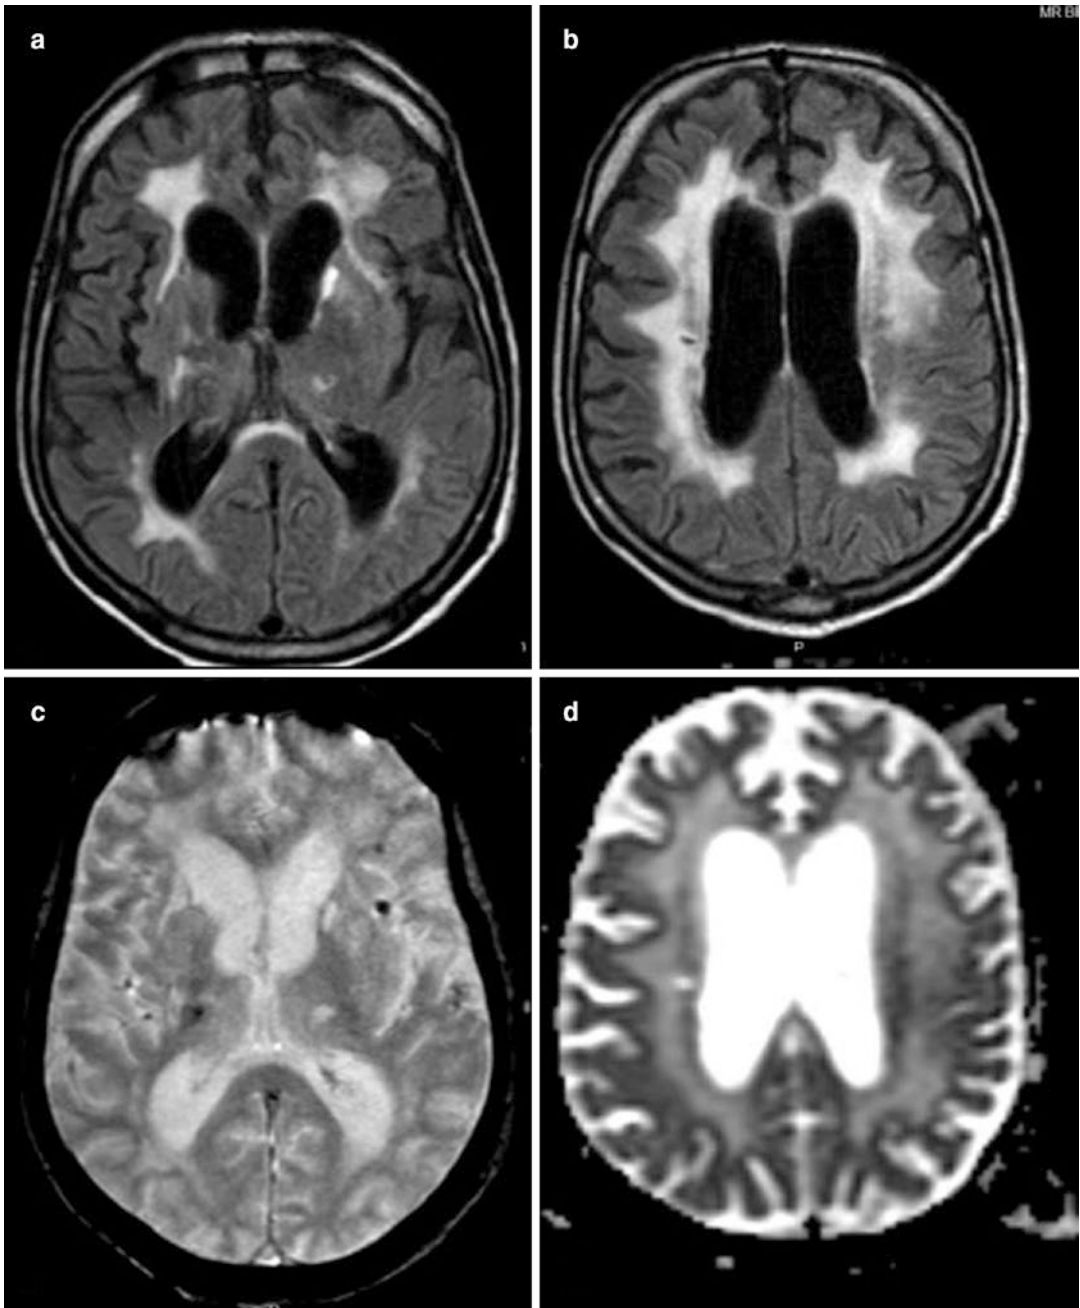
Severe SIVD consistent with Binswanger disease. FLAIR (a, b), GRE (c), and ADC map (d) in 71-year-old male with essential hypertension and systemic vasculopathy
